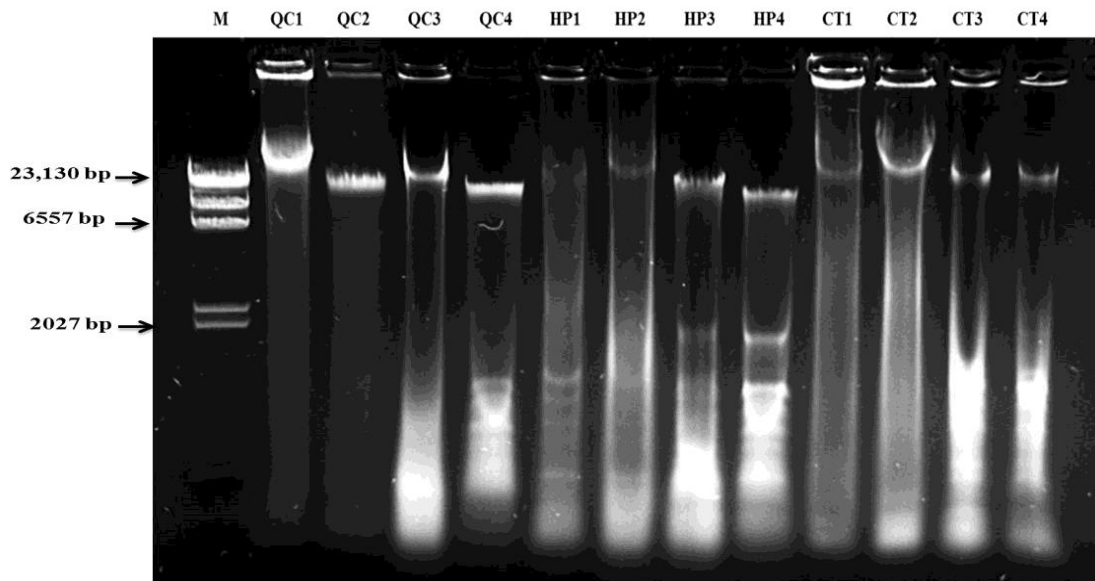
Total genomic DNA extracted from *D. alata* and *D. rotundata* using three methods, namely; Qiagen Tip100/G column purification of extracted DNA (QC), modified CTAB method on HEPES-treated leaf (HP) and modified CTAB method (CT). All PCR products were electrophoresed through a 0.8% (w/v) agarose in 0.5x TBE gel. Lane M = lambda *Hind*III ladder (NEB, UK), lane QC1, HP1 and CT1 = *D. rotundata* sample (G9), lane QC2, HP2 and CT2 = *D. rotundata* sample (G12), lane QC3, HP3 and CT3 = *D. alata* sample (G5) and lane QC4, HP4 and CT4 = *D. alata* sample (G16).
